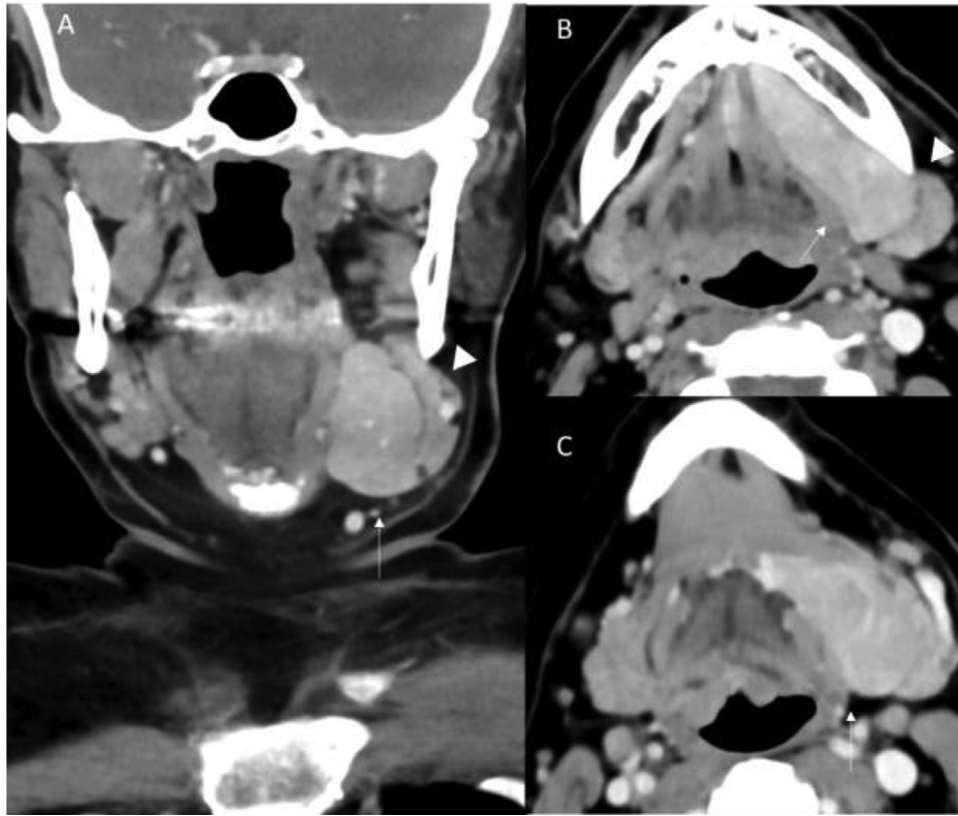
Coronal (A) and axial (B, C) contrast-enhanced CT neck images depicts the well-circumscribed homogenous mass (arrows) along the left floor of mouth extending into submandibular region. The lesion can be seen separately from the submandibular gland (arrowhead).
